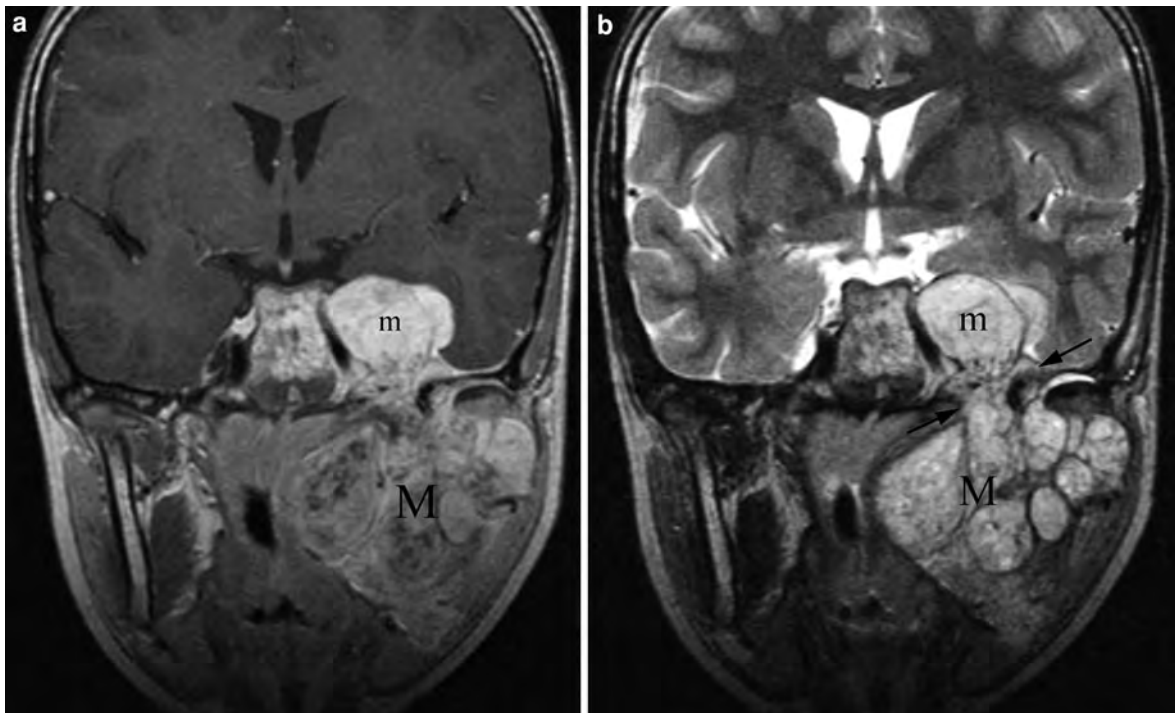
Gadolinium enhanced, coronal T1- (a) and T2-weighted (b) images through the central skull base show a large, markedly enhancing left cavernous sinus mass on the left (*m* in a and b) that extends through the foramen ovale (arrows in b) along the mandibular division of the trigeminal nerve to completely occupy
